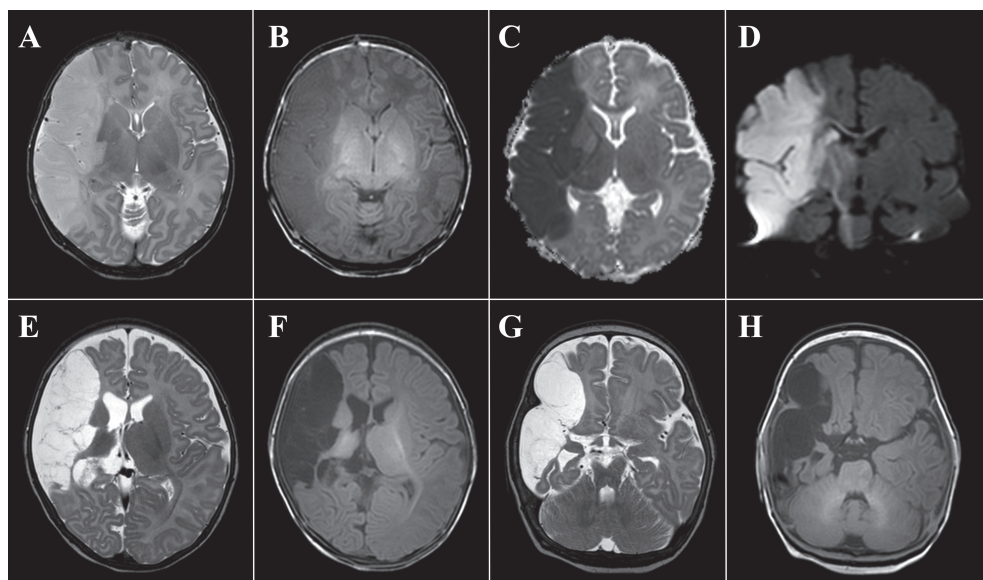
MRI findings in an infant with PAIS. An infant presented with hemi convulsions in the left arm and leg at 26 hours after birth. The MRI, including T2-weighted imaging (A), T1-weighted imaging (B) and diffusion-weighted imaging (ADC map) (C), was performed at 72 hours after initial presentation and showed a main branch middle cerebral artery stroke in the right hemisphere. DWI shows clear restricted diffusion in the descending corticospinal tract, referred to as “pre-Wallerian” degeneration (D). Three months later, a follow-up MRI was performed that demonstrated cystic evolution of the middle cerebral artery territory (E+F), including atrophy of the basal ganglia and thalamus. At three months of age, multicystic encephalomalacia can be seen in the former stroke area (F). Degeneration of the corticospinal tract (Wallerian degeneration) led to atrophy of the right cerebral peduncle (G) and base of the pons (H). This child was at high risk of an adverse outcome, and was eventually diagnosed with cerebral palsy and cognitive deficits at the age of two.
